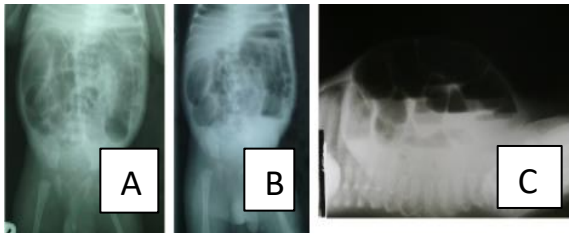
Plain abdominal radiographs for neonatal intestinal obstruction; A is the supine view, B is erect view and C is cross-table lateral view. A shows dilated bowel loops while both Band C show multiple air-fluid levels
